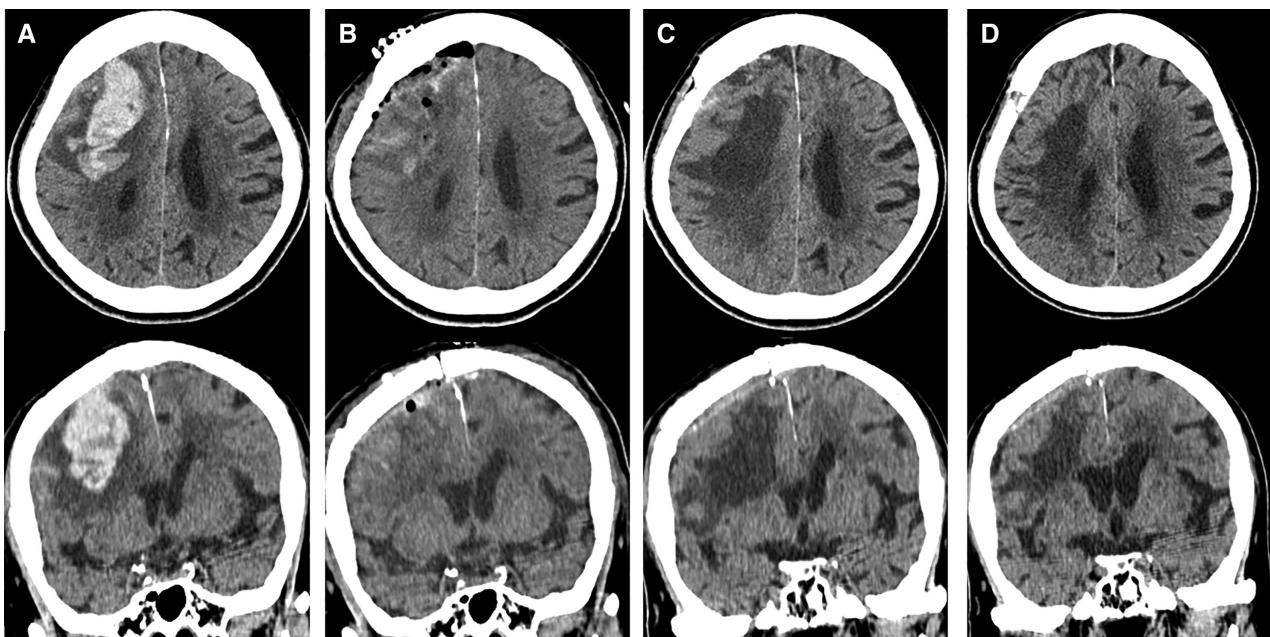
Brain CT on day 1 after admission (A) and postoperative day 1 (B). (C) Brain CT on postoperative day 15 showing the cyst in the hematoma cavity. (D) Brain CT on postoperative day 25 indicating cyst shrinkage after steroid treatment. CT: computed tomography.
